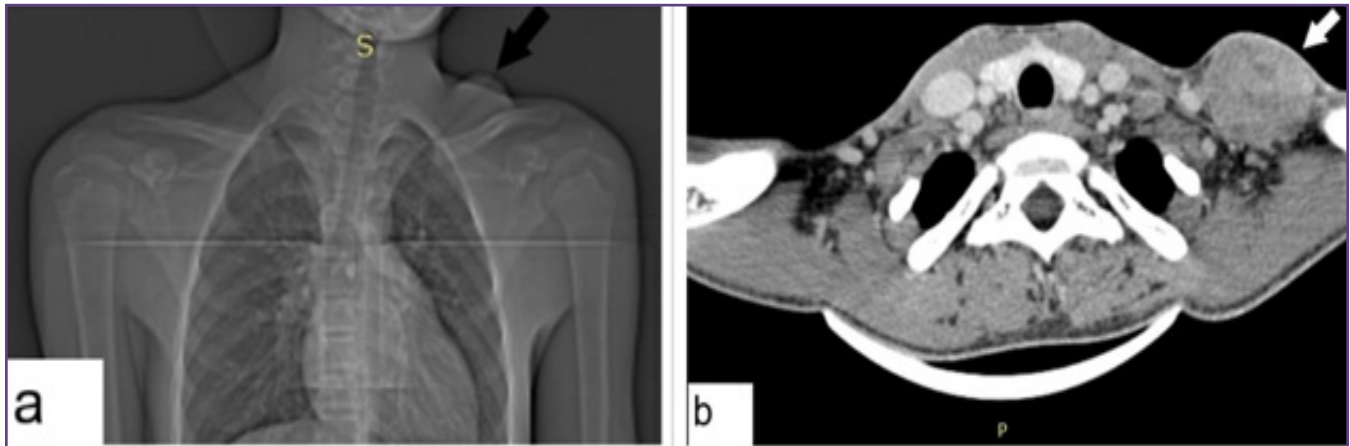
(a) CT scan topogram shows a left supraclavicular swelling (Black arrow). (b) CECT neck shows a well - defined, oval, solid lesion, measuring 3.7x4.2x4.2 cm in left supraclavicular region (white arrow) with heterogenous post contrast enhancement and non - enhancing areas within.
